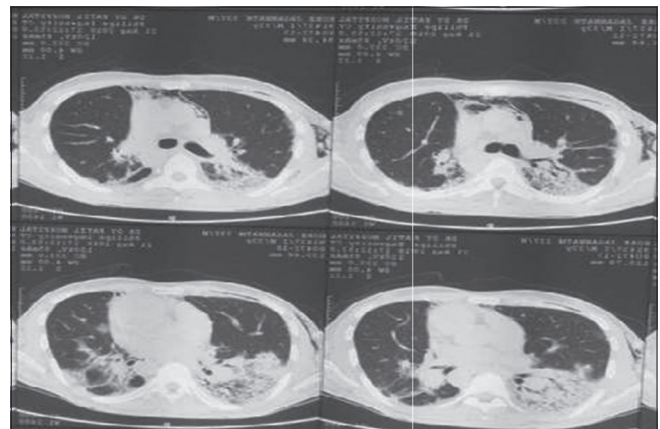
Computed tomography thorax images in case one
